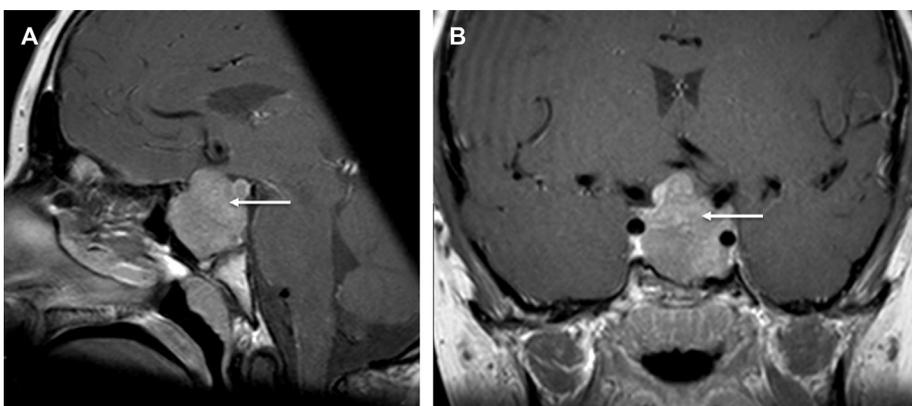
Macroprolactinoma. MRI sagittal (A) and coronal (B) T1W sections after injection of gadolinium showing a macroprolactinoma with suprasellar extension (white arrow).
